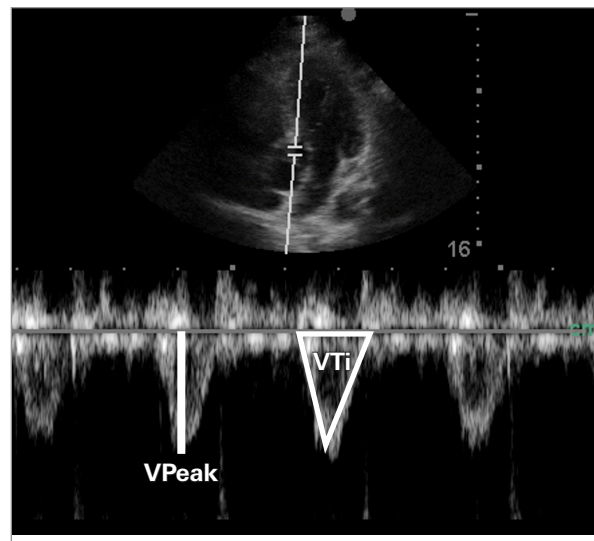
Transthoracic echocardiogram with pulsed wave Doppler of the left ventricular outflow tract identifying peak velocity (VPeak) and velocity time integral of the Doppler tracing (VTi).
